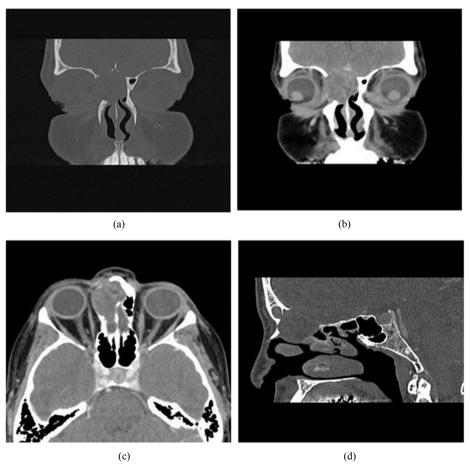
Sinonasal schwannoma. Unenhanced coronal (a) maxillofacial CT image demonstrates a right ethmoidal sinonasal schwannoma with soft tissue attenuation. Enhanced coronal (b) and axial (c) images show heterogeneous enhancement of the mass. Unenhanced sagittal (d) CT shows intracranial extension of the mass with surrounding benign bony remodeling.
